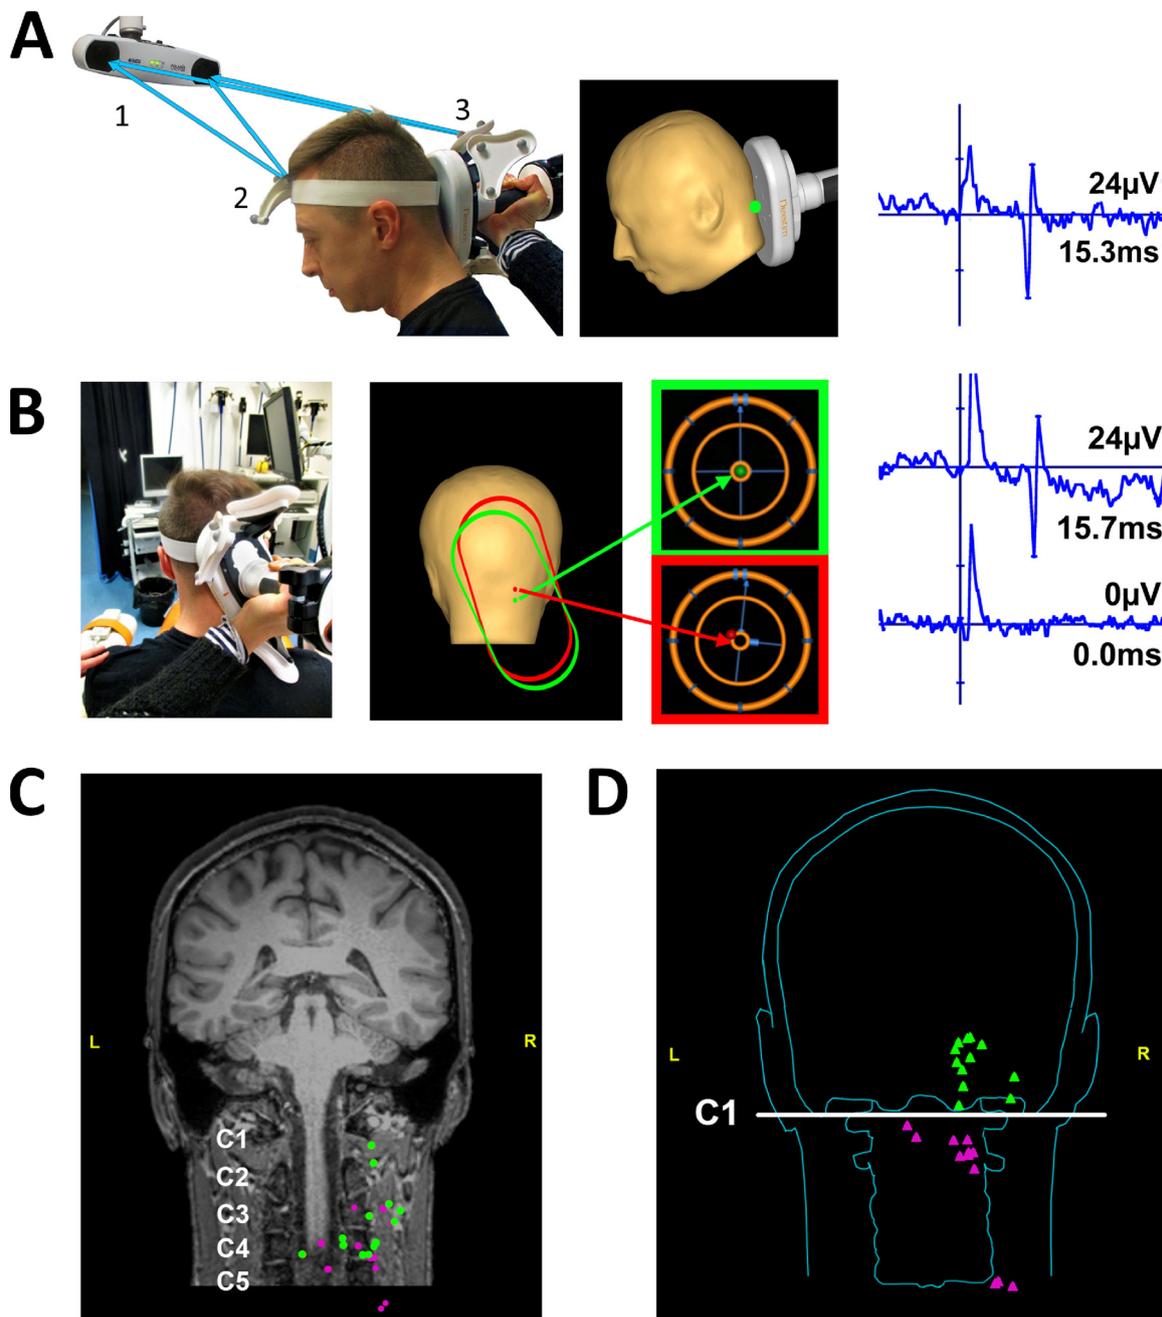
Location-controlled stimulation. A) Left: position of the tracking unit (1), the head tracker (2) and the stimulation coil (3) for optimal stimulation at the level of the cervical spine. The blue arrows show how the real-time position of the coil with respect to the subject’s head is defined. Middle: MRI-based 3-D model of the subject’s head (center of the coil is the site where the magnetic stimulus induced a MEP and is marked with a green dot). Right: EMG signal from the NBS software. MEP (amplitude 24 µV; latency 15.3 ms) elicited by the stimulus is visible (note the unipolar stimulus artefact preceding the bipolar response).
